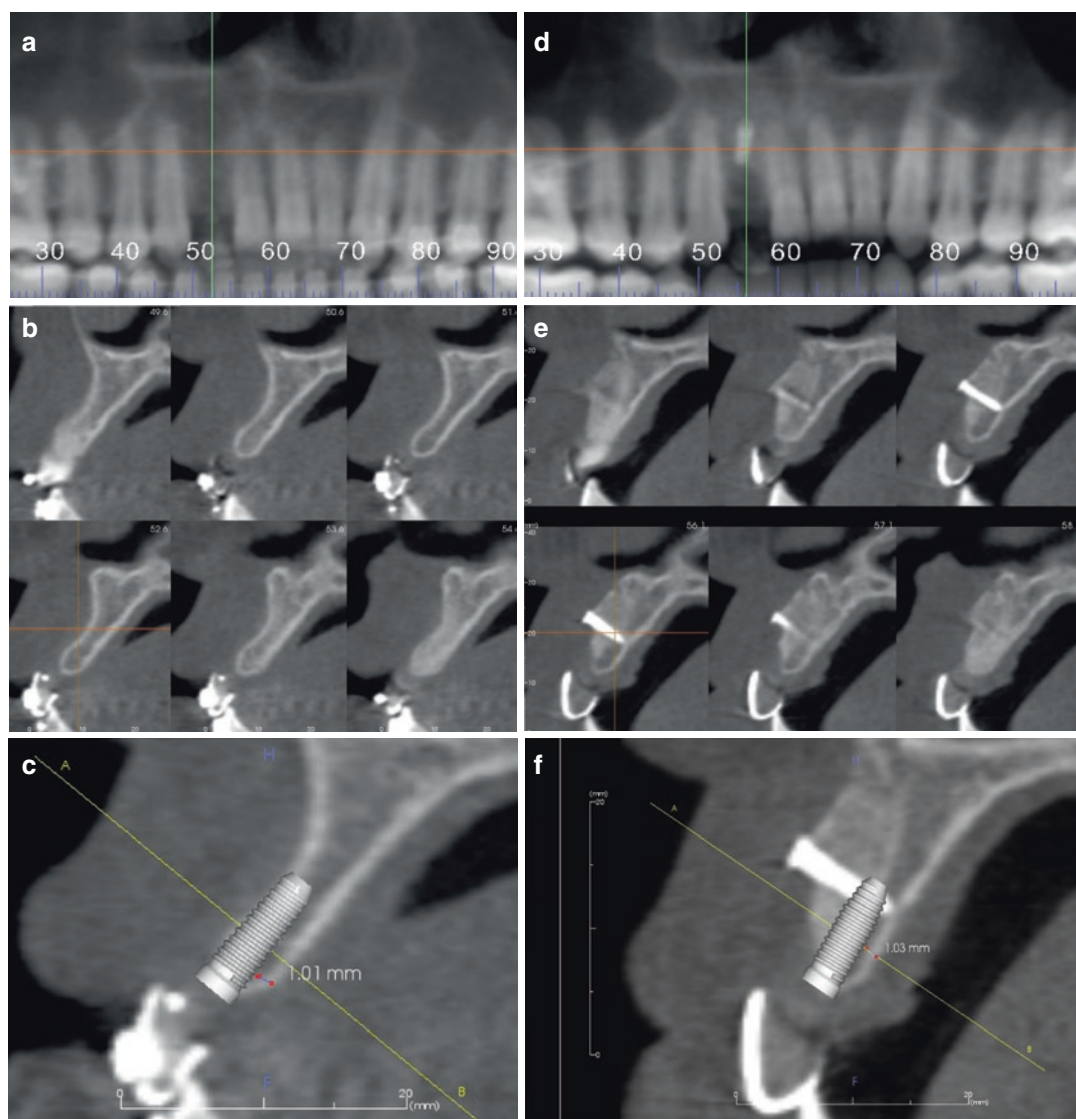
Reformatted panoramic (a) and serial cross-sectional 1 mm thickness and 1 mm intervals (b) CBCT images showing the 5-month postoperative imaging appearance of the left maxillary anterior region. The patient presents with an extensive history of left facial trauma with root canal therapy and ultimate loss of the left maxillary left central and then lateral incisor teeth. Initially particulate bone grafting was performed which failed. Most recently a tibia graft was performed to reconstruct the edentulous alveolar defect. There is a
